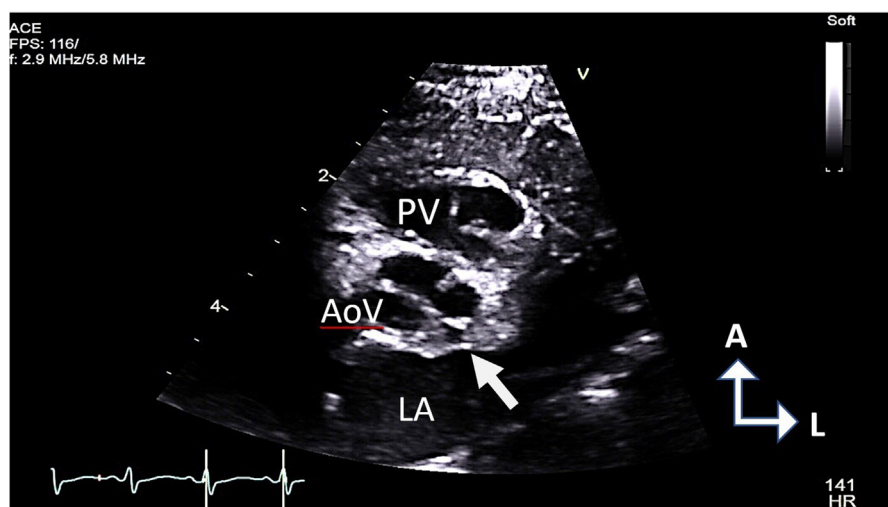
Parasternal short-axis view demonstrates quadricuspid leaflets with 3 equal leaflets and a smaller left posterior leaflet (arrow) entrapping the left coronary ostium. A, Anterior; AoV, aortic valve; L, left; LA, left atrium; PV, pulmonary valve.
